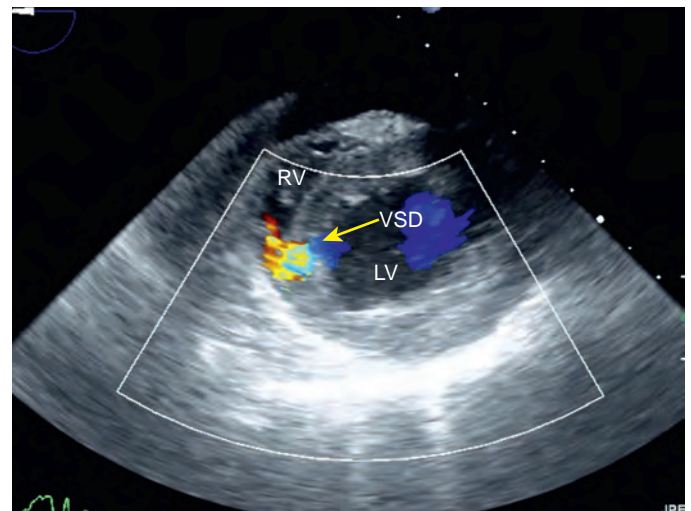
Transgastric mid-short-axis view with color-flow Doppler shows flow across a postinfarction ventricular septal defect (VSD). A pericardial effusion is also visualized. LV, Left ventricle; RV, right ventricle.
